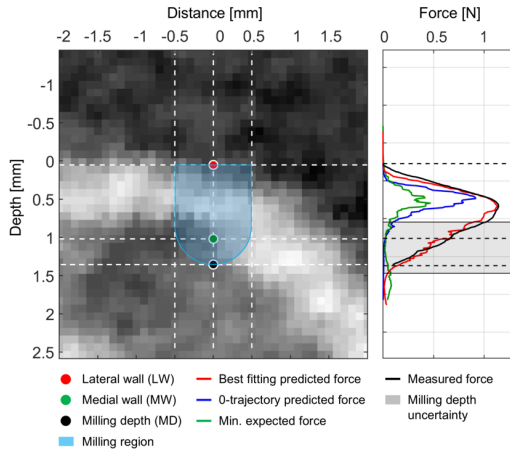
Left: Pre-operative CT image of one subject showing the planned trajectory and milling region for inner ear access with the corresponding transitions depths determined by the refinement algorithm. Right: Predicted and measured force profile shapes (0-trajectory = planned optimal trajectory).
